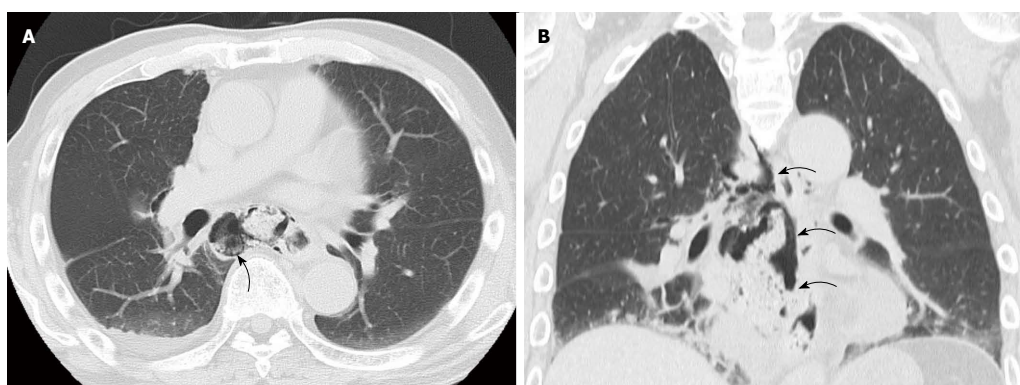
Enhanced computed tomography showed food residue in his mediastinum (arrow) (A) and mediastinal emphysema (arrow) (B).
